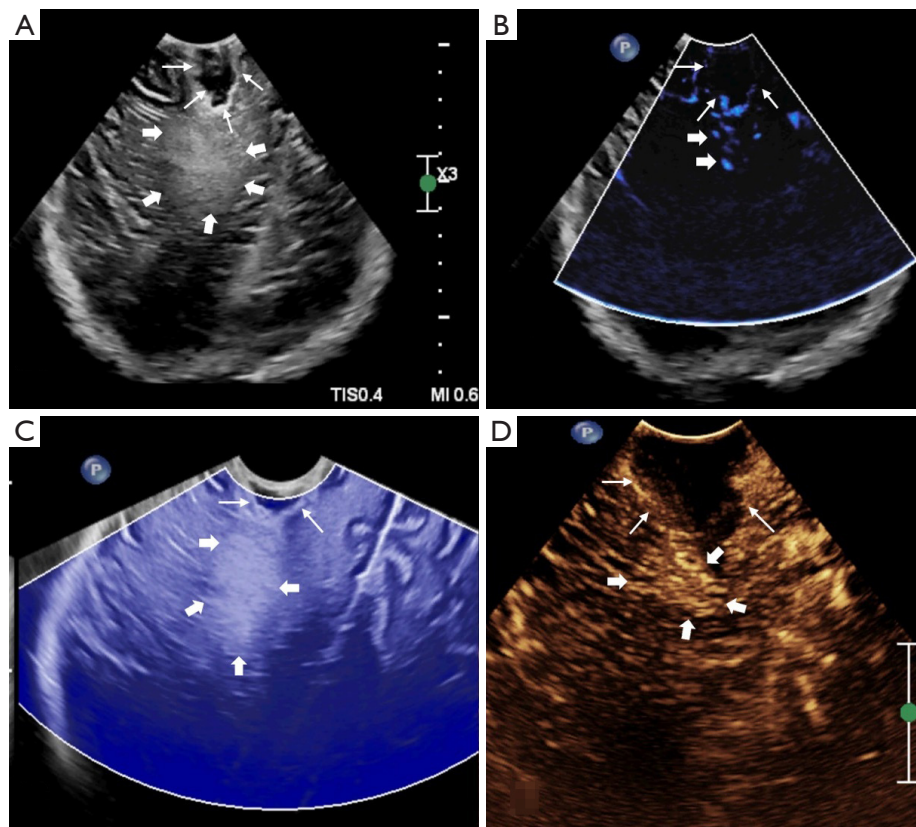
Images of a 68-year-old male with diffuse large b-cell lymphoma who had tumor residue after neurosurgery. (A) The tumor residue was clear on the B-mode image; (B) the tumor residue showed intralesional vascularization on micro-flow imaging; (C) young's modulus value of the tumor residue and normal brain tissue showed no difference on the SWE image. Thus, the tumor residue was not clear on the SWE image; (D) the tumor residue showed high enhancement on the CEUS image. Thick arrows indicate the tumor residue and thin arrows indicate the surgical cavity. CEUS, contrast-enhanced ultrasound; SWE, shear wave elastography.
